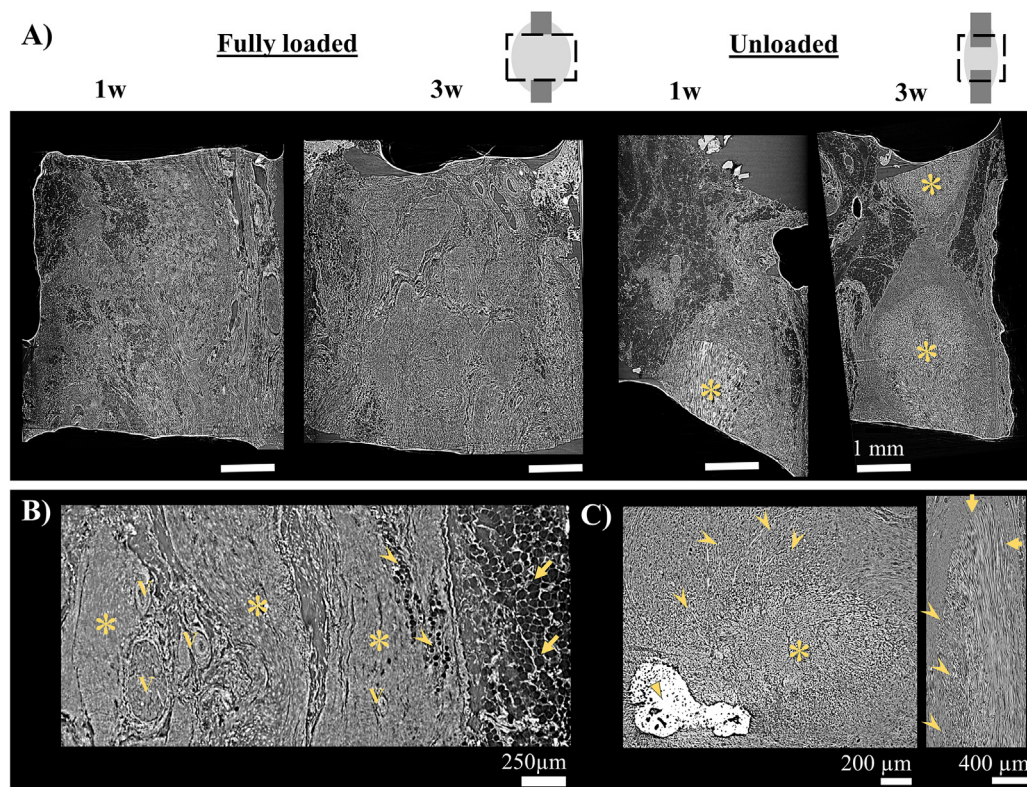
Visualization of microscale organization of healing tendons by SR-PhC- μ CT. A) Central longitudinal views of healing tendons at 1 and 3 weeks exposed to full loading (FL) or unloading (UL), showing the microscale organization of the collagen fibers, adipose tissue and blood vessels. Intact stumps are visible (*) in the UL tendons. B) Compartments of forming fibers (*), blood vessels (v) and adipose tissue within (arrowheads) and on the side (arrows) of the 3 weeks FL healing tendon. C) Signs of integration of the stump with surrounding callus tissue in the 3 weeks UL healing tendon, occurring at one lateral side of the stump (arrowheads), but not on the upper side on the stumps (arrows). A calcified deposit was present in the lower stump (triangle).
